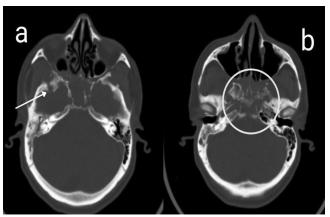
Axial non contrast CT image of brain in bone window at the level of base of skull showing bone erosions (a)in greater wing of right sphenoid bone(arrow), (b)clival and sellar regions(circle).
